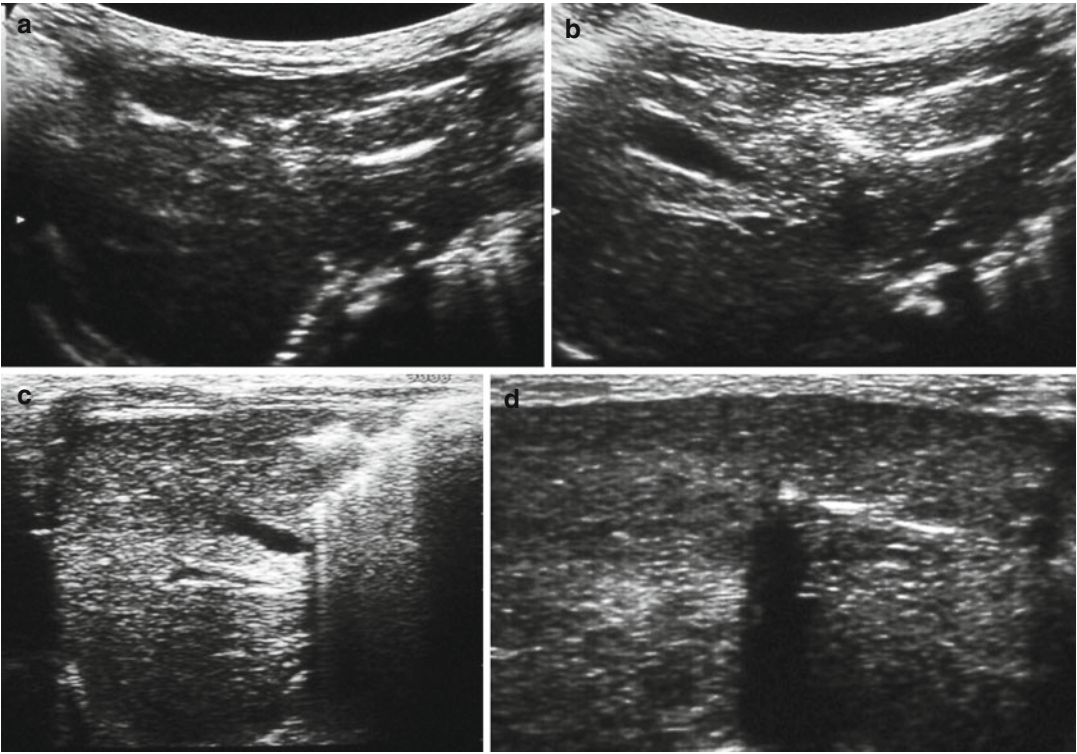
(a–d) Ultrasound exam in newborn with NEC shows portal pneumatosis as hyperechoic linear imaging in portal spaces
